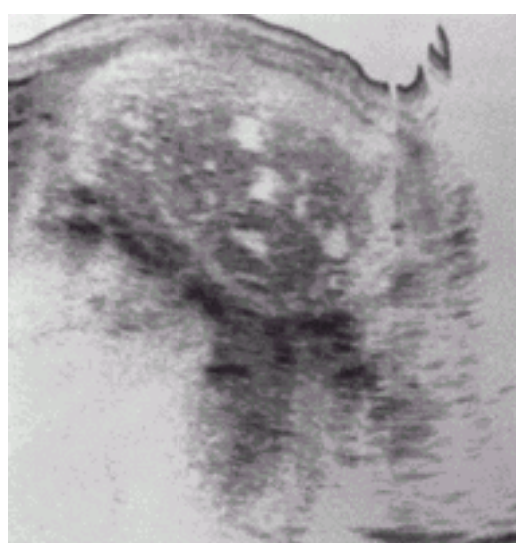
Longitudinal ultrasonography reveals a hydatidiform mole. The mixed echogenic pattern is caused by hydropic villi and focal intrauterine hemorrhage.
